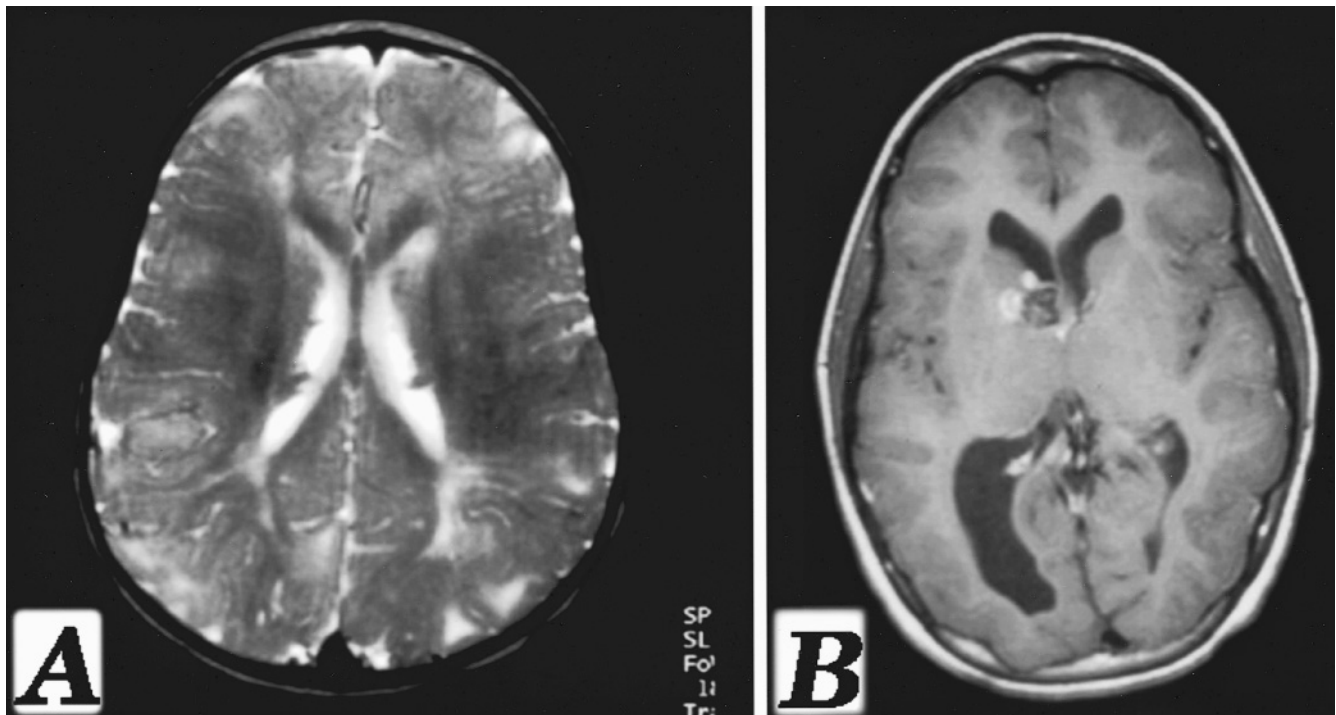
A*, Axial T₂-weighted magnetic resonance image (MRI). Subependymal nodules seen along the periventricular margin as low-signal nodules. Tubers are seen as subcortical, cortical, and high-signal lesions. Migration lines extend from the posterior atria toward the parietal cortex. *B*, Axial T₁-weighted MRI with contrast enhancement. Subependymal giant cell astrocytoma seen at the right foramen of Monro.
